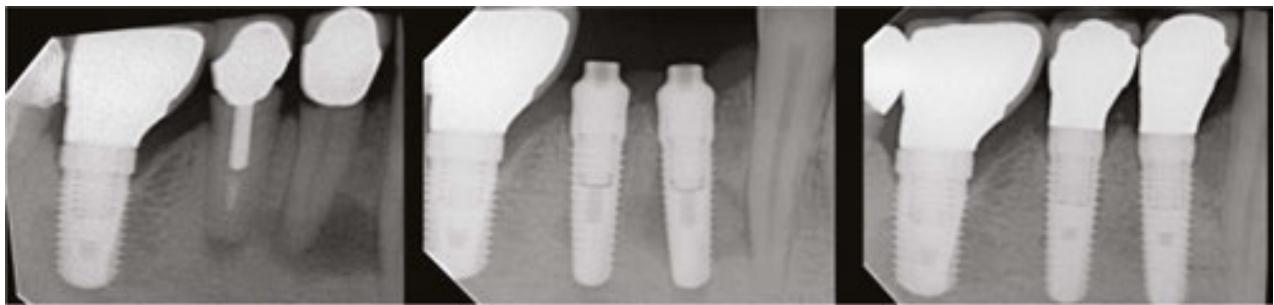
The radiographic series shows good healing. The molar implant was one with a 1.4 mm machined collar placed five years earlier.
